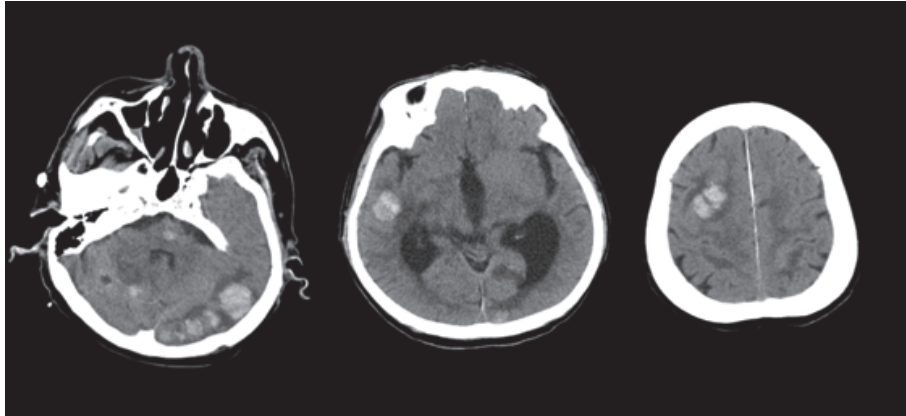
Computed tomography scan performed 3 weeks after admission revealed that the number of cerebral hemorrhages was increasing.
